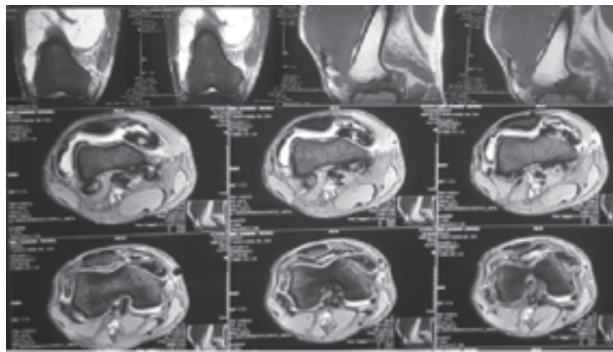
2 MRI of knee joint- Coronal, Sagittal and Axial view
